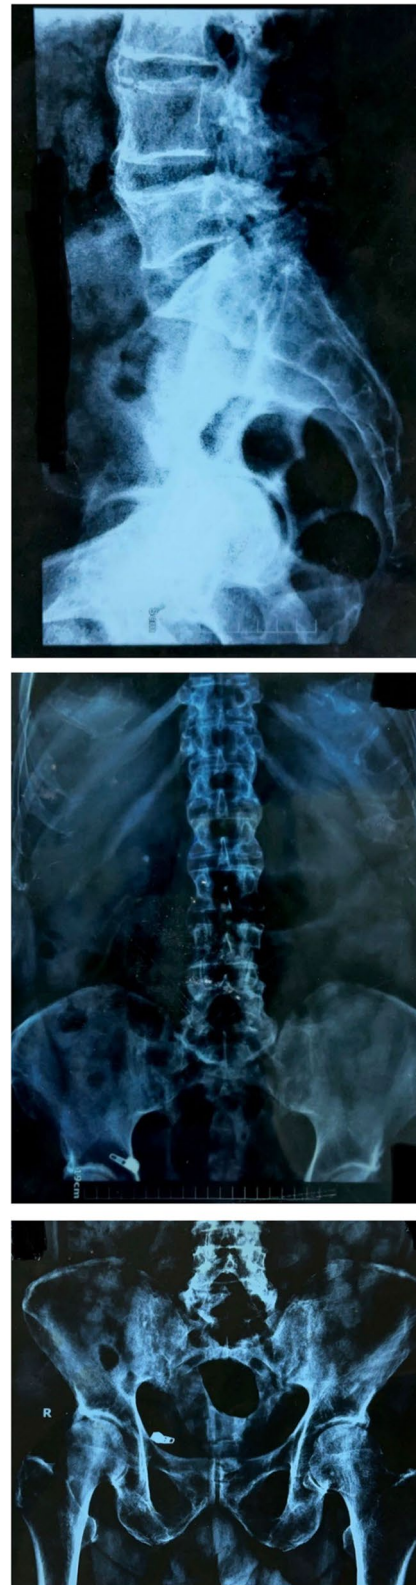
X-ray of lumbar spine
